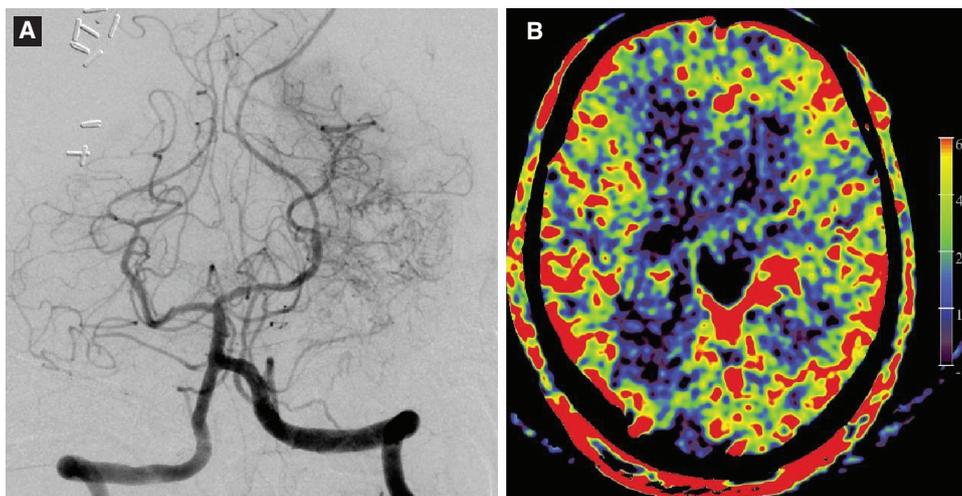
(A) A right vertebral angiogram after the treatment demonstrating recanalization of the left posterior cerebral artery. (B) An image of flat detector CT perfusion after the treatment revealing normalization of cerebral blood volume in the left occipital lobe.
